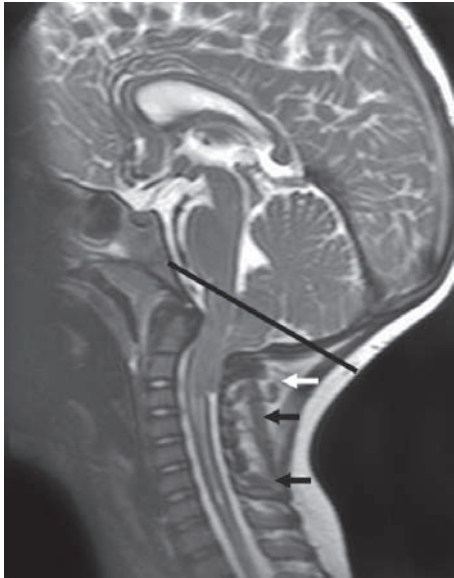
Chiari I malformation on sagittal T2-weighted MR image. The cerebellar tonsil (white arrow) extends well below the foramen magnum (black line). The high signal within the cervical cord (arrowheads) indicates the presence of a syrinx
